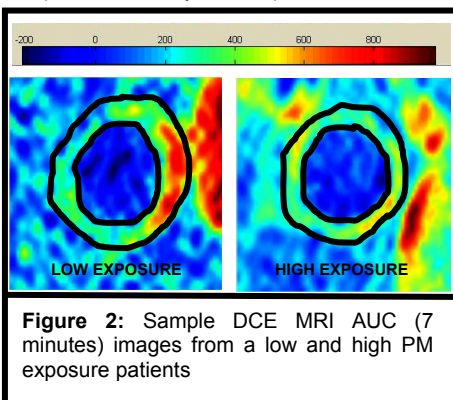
Sample DCE MRI AUC (7 minutes) images from a low and high PM exposure patients
